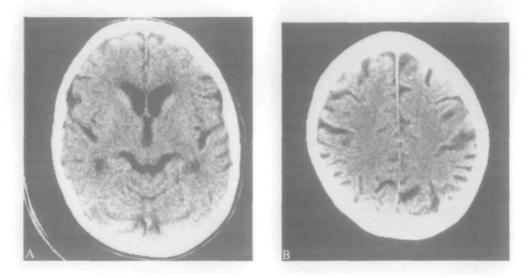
A, B, CT scan of patient showing diffuse cerebral atrophy.
